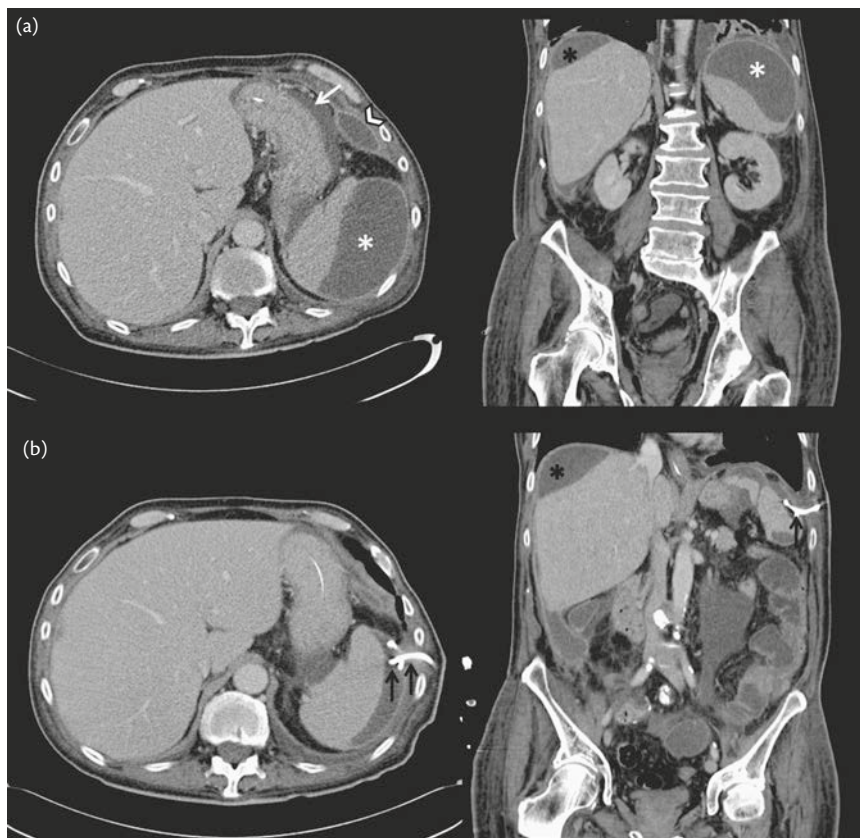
(a) Axial and coronal CT sections of an ICU patient with anastomotic leak after right hemicolectomy. Note the walled-off left subphrenic abscess (*) adjacent to the spleen. Another smaller right subphrenic collection also seen (black *). A small rim of free ascites is seen around the greater curve of the stomach (white arrow). (b) Post-catheter drainage of the left subphrenic abscess—the collection has reduced significantly with a drain *in situ* (black arrows). Note the right subphrenic collection (black *) has slightly increased and subsequently drained.
